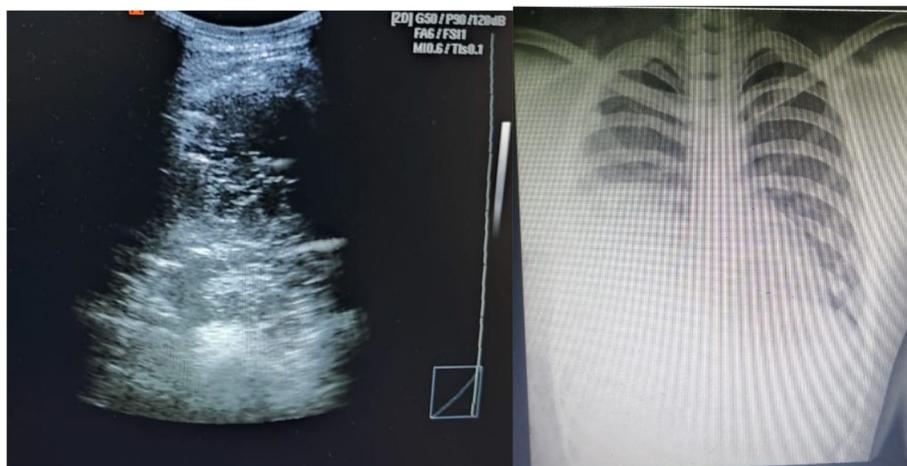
Chest US and chest X-ray in a patient with pulmonary consolidation
